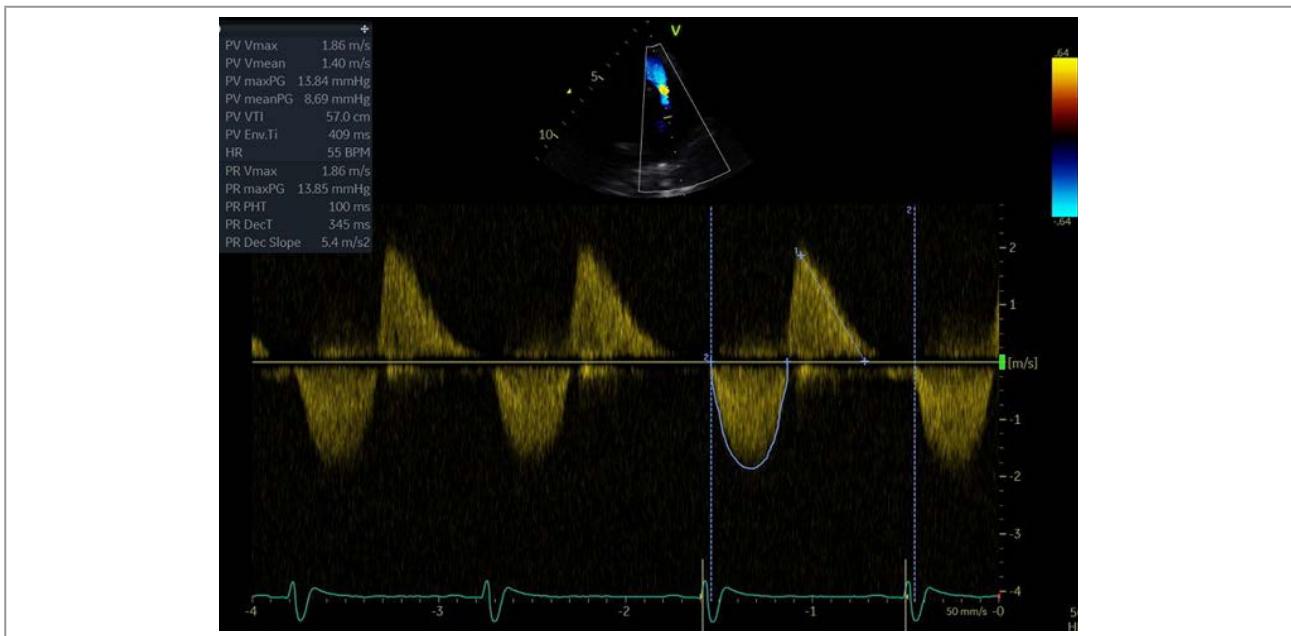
Continuous wave Doppler over the pulmonary valve showing a low systolic gradient over the valve (8 mmHg) but severe pulmonary regurgitation with a pressure half-time of 100 ms.
